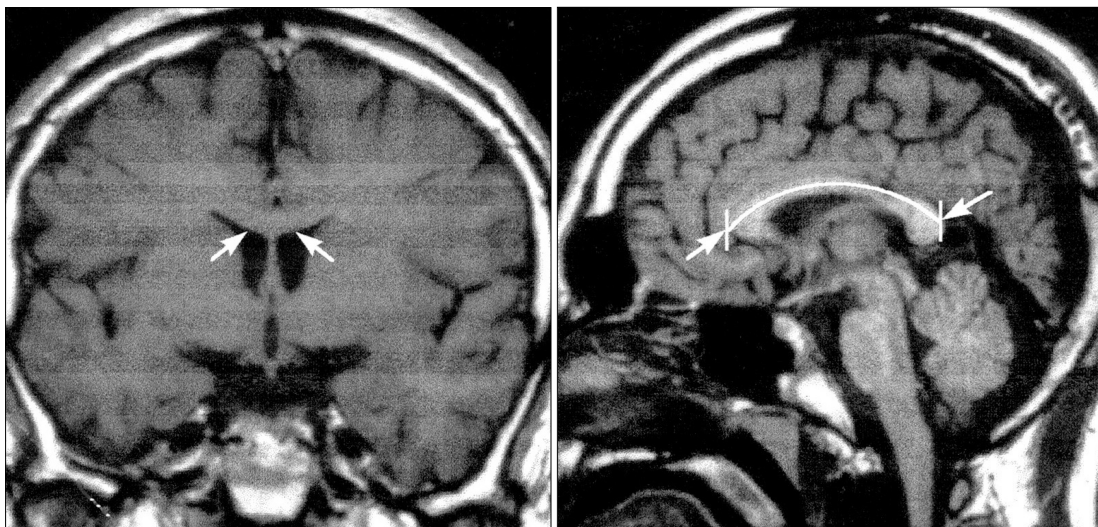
Measurement of corpus callosum in sagittal view of MRI ; The corpus callosum has a mean length of 65.7 (59.4 to 81.2)mm.
